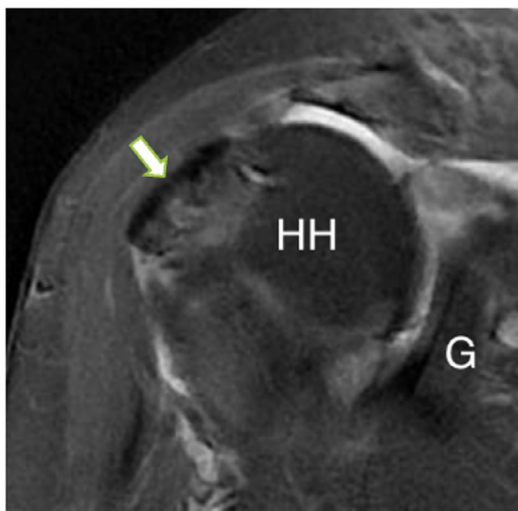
T2-weighted coronal oblique MRI of a right shoulder 7 months following surgery showing complete healing of the graft (arrow) to the greater tuberosity of the humeral head (HH). G—glenoid.
